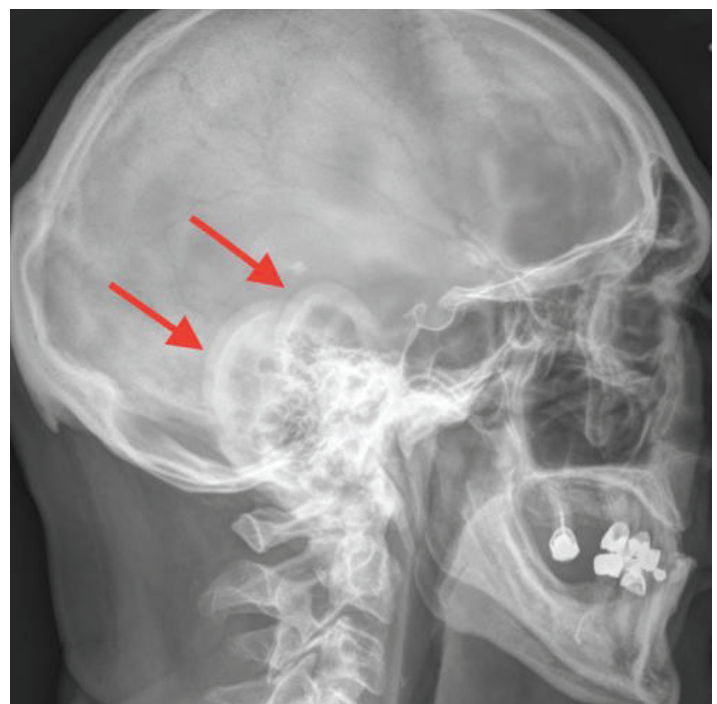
Skull radiograph demonstrated opacities in the bilateral cartilaginous structures of the ear, consistent with aberrant bone deposition into auricular cartilage.
